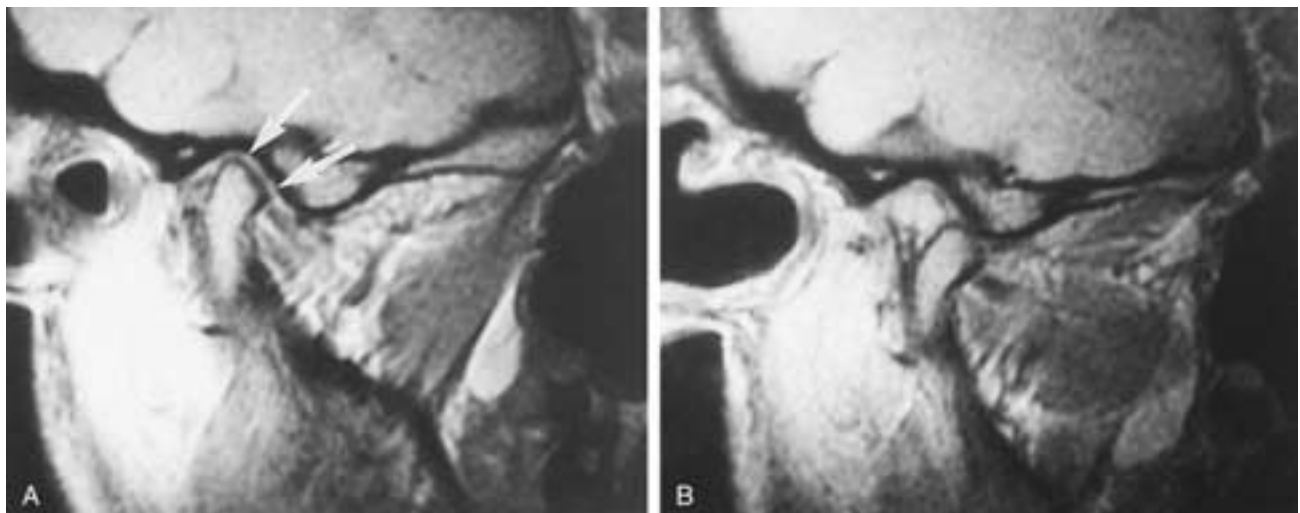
Successful diskectomy. A, Closed-mouth MR image shows an area of intermediate to high signal (*arrows*) in the joint space. This is the normal appearance after a successful diskectomy. B, On opening, the condyle translates anteriorly and inferiorly, and there is no evidence of fibrous ankylosis.
